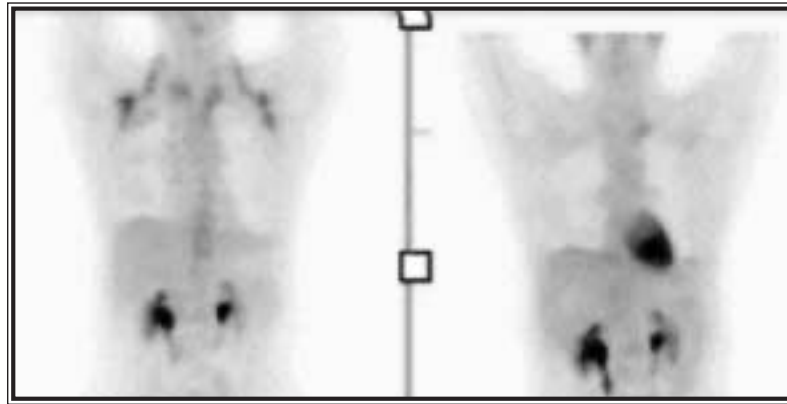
Patient was being evaluated for lymphoma. Initial FDG-PET scan (left) demonstrates increased neck and supraclavicular activity, which may represent muscle uptake or brown fat. These findings disappear in repeat scan after administration of diazepam, possibly related to muscle relaxation or direct effect of diazepam on brown fat.
